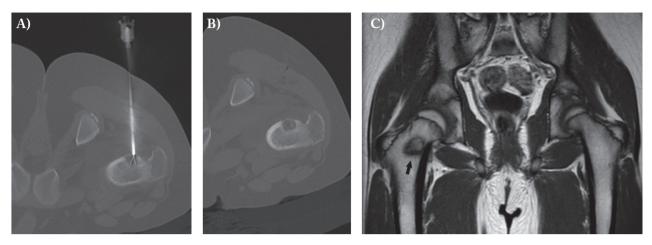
Osteoid osteoma of the right femoral neck. 12 year old male suffering from right hip pain irradiated to the omolateral thigh for several months was referred to our center for percutaneous treatment of an osteoid osteoma of the femoral neck; note that in this location osteoid osteoma generally shows less or absent peripheral sclerosis. (A) Radiofrequency ablation was achieved via a posterior trans-gluteal approach. (B) Post-procedural control CT scan. (C) 30 days post-treatment MRI showing regular outcomes of intervention (arrow)
